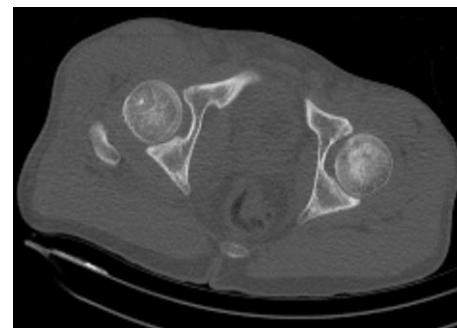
Post reduction pelvic axial CT scan, congruent hip joint without any associated fractures
